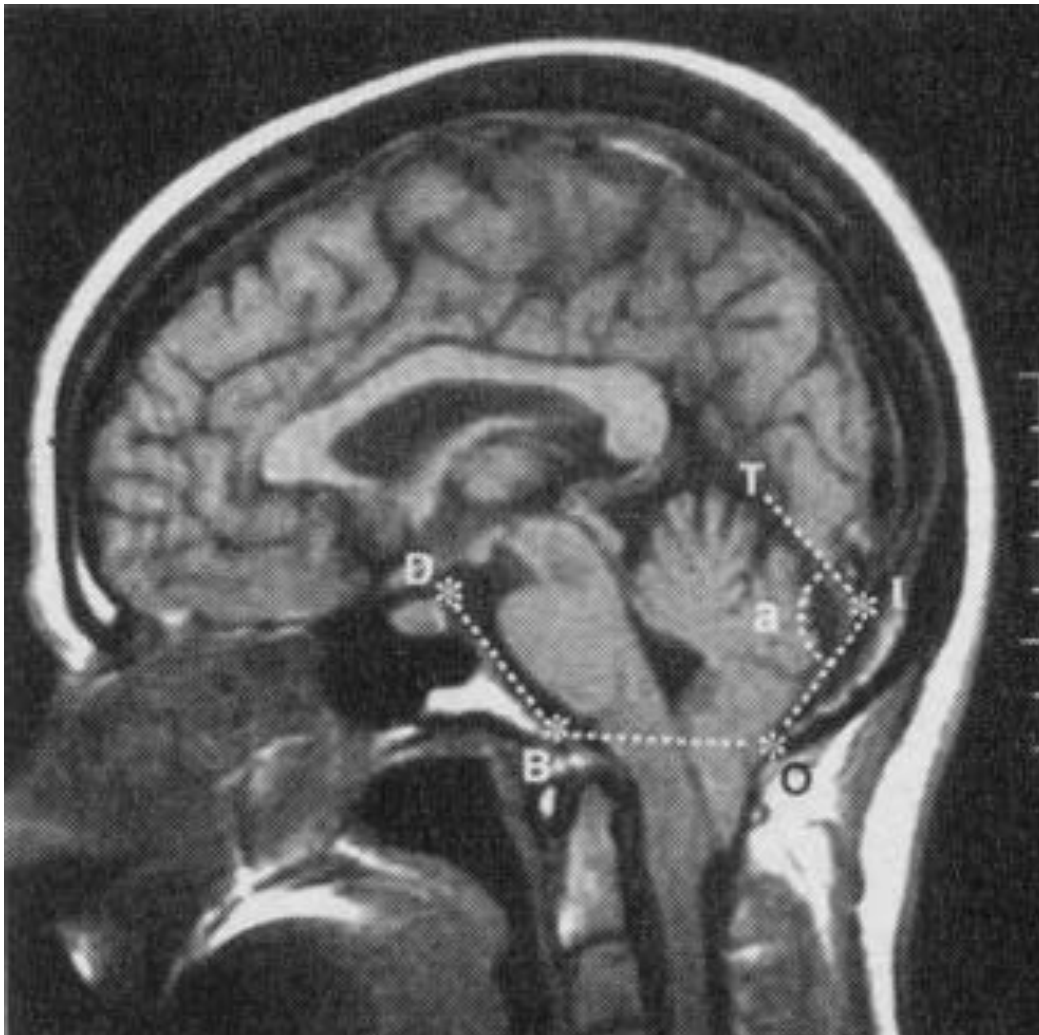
Measurements of posterior cranial fossa morphological characteristics using T1-weighted sagittal MRI scans of a 44-year-old female patient with Chiari I malformation. The length of the supraocciput (IO) was measured along a line drawn from the center of the internal occipital protuberance (I) to the opisthion (O). The length of the clivus (DB) was measured along a line drawn from the top of the dorsum sellae (D) to the basion (B). The slope of the tentorium (T) was calculated by measuring the angle (a) formed by the tentorium and the supraocciput. The extent of tonsillar herniation was measured from the tips of the cerebellar tonsils to a line drawn between the basion and the opisthion. Findings in this case consisted of a short supraocciput, increased slope of the tentorium, hypoplasia of the clivus, and descent of the cerebellar tonsils 1.6 cm below the foramen magnum (Milhorat et al., 1999).
